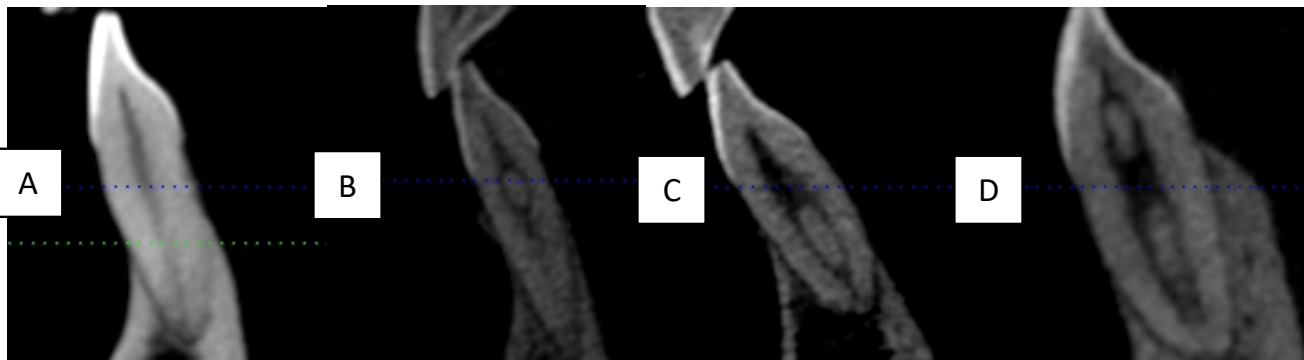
CBCT Images of Mandibular incisors: (A) type 1; (B) type 2; (C) type 3; (D) type 6.
